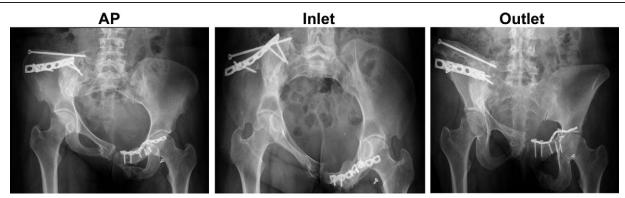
Preoperative radiographs indicating the vertical, anterior-posterior (AP), and rotational displacement.
